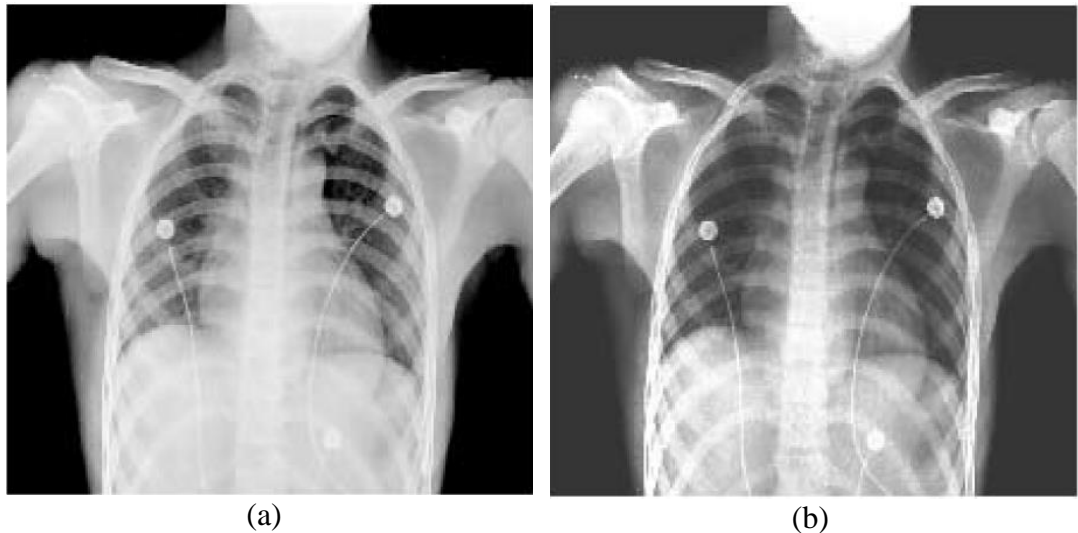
Examples of contrast enhancement on medical images. (a) A chest X-ray-Vandy image. (b) After contrast enhance [131].
